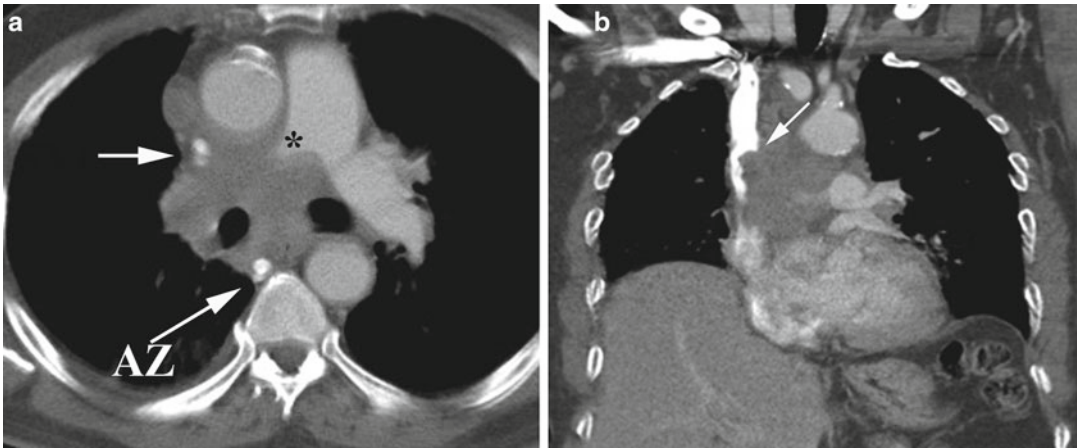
Superior vena cava (SVC) obstruction. (a) Axial CT image reveals large mass surrounding and narrowing the SVC (arrow) as well as obstructing the right pulmonary
